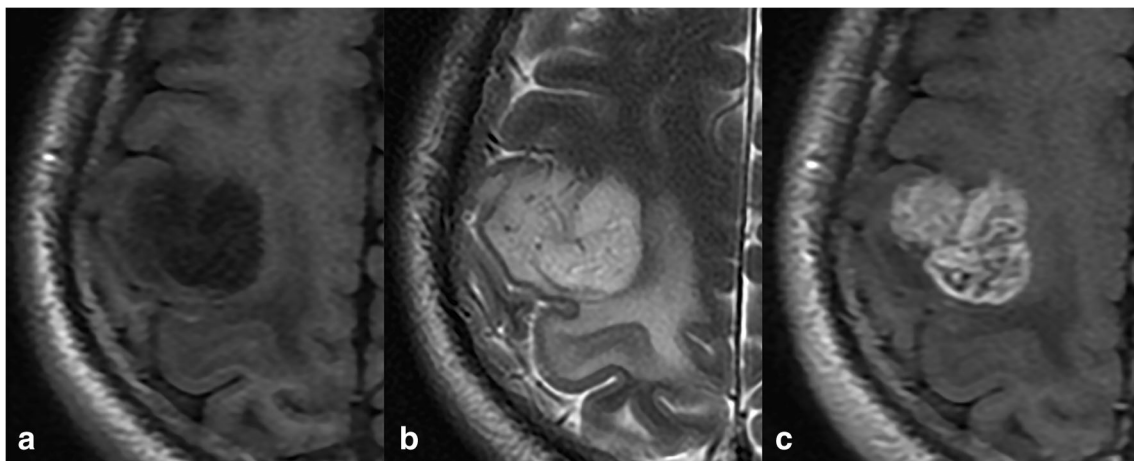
Brain magnetic resonance imaging revealed a lesion in the right motor functional cortex with a low-intensity signal during T1-weighted imaging (a), a high-intensity signal during T2-weighted imaging (b), and a heterogeneous signal during enhancement (c)
